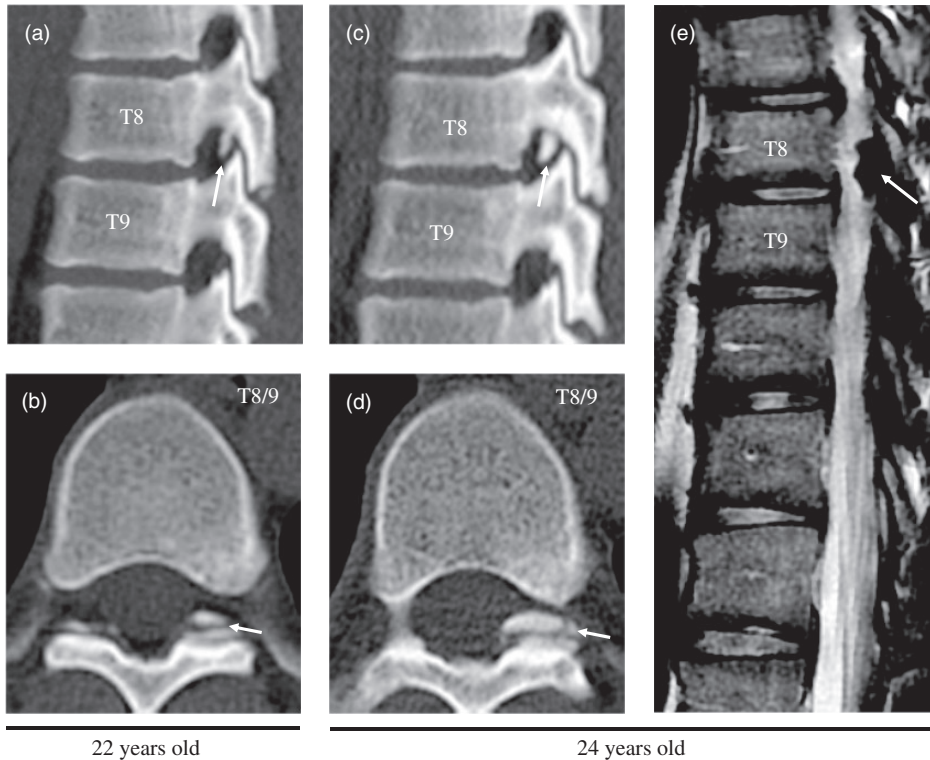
Case 2: Radiological findings in the thoracic spine on computed tomography and magnetic resonance imaging revealing the presence of ossification of the ligamentum flavum (arrows). Left parasagittal view (a) and axial view at T8/9 (b) when the patient was 22 years old. Left parasagittal view (c, e) and axial view of the spine at T8/9 (d) when the patient was 24 years old.
